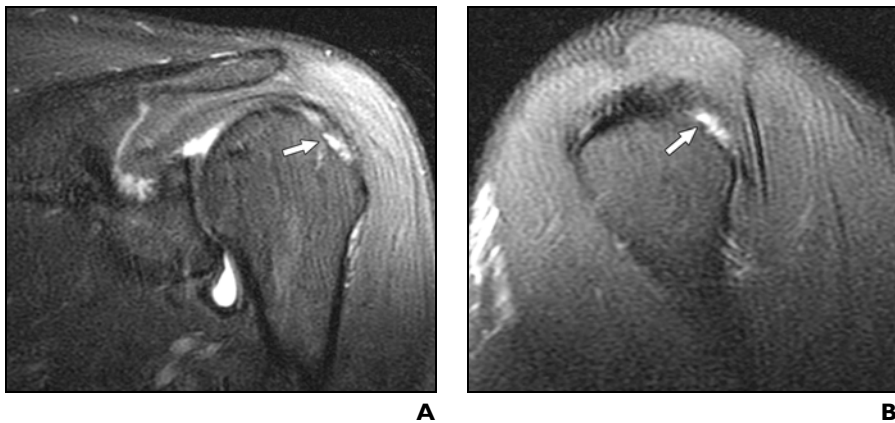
38-year-old man with rim-vent tear of infraspinatus tendon. A and B, Fat-suppressed fast spin-echo T2-weighted coronal oblique (TR/TE, 4,000/65) (A) and sagittal oblique (3,000/74) (B) MR arthrography images show rim-vent tear (*arrows*) at insertion of infraspinatus tendon onto greater tuberosity. This tear was not seen prospectively but was diagnosed at time of surgery.
